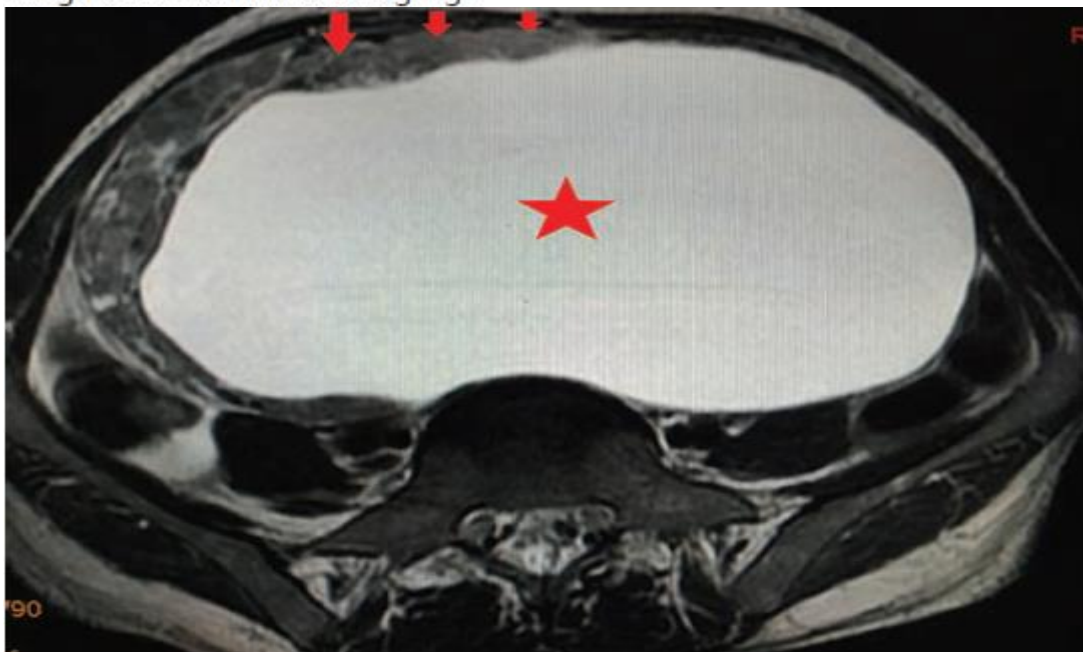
Axial T2-W MRI demonstrating a well-defined hyperintense adnexal cyst (star) of ovarian origin. Mural nodule (arrows) is seen anterolaterally. MRI, magnetic resonance imaging.
